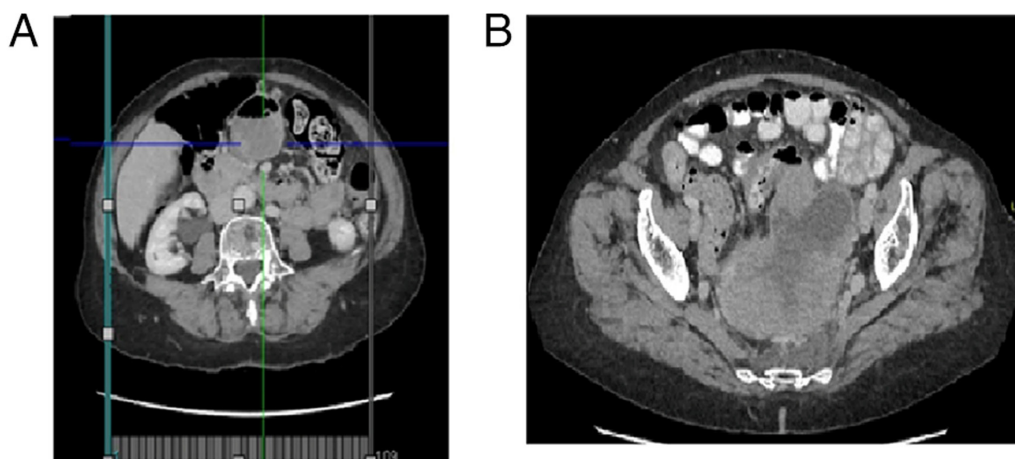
Computed tomography of the pelvic mass. (A) Tumor with intestinal involvement and adenopathies. (B) Polyglobulated mass in the pelvis with necrosis areas.
